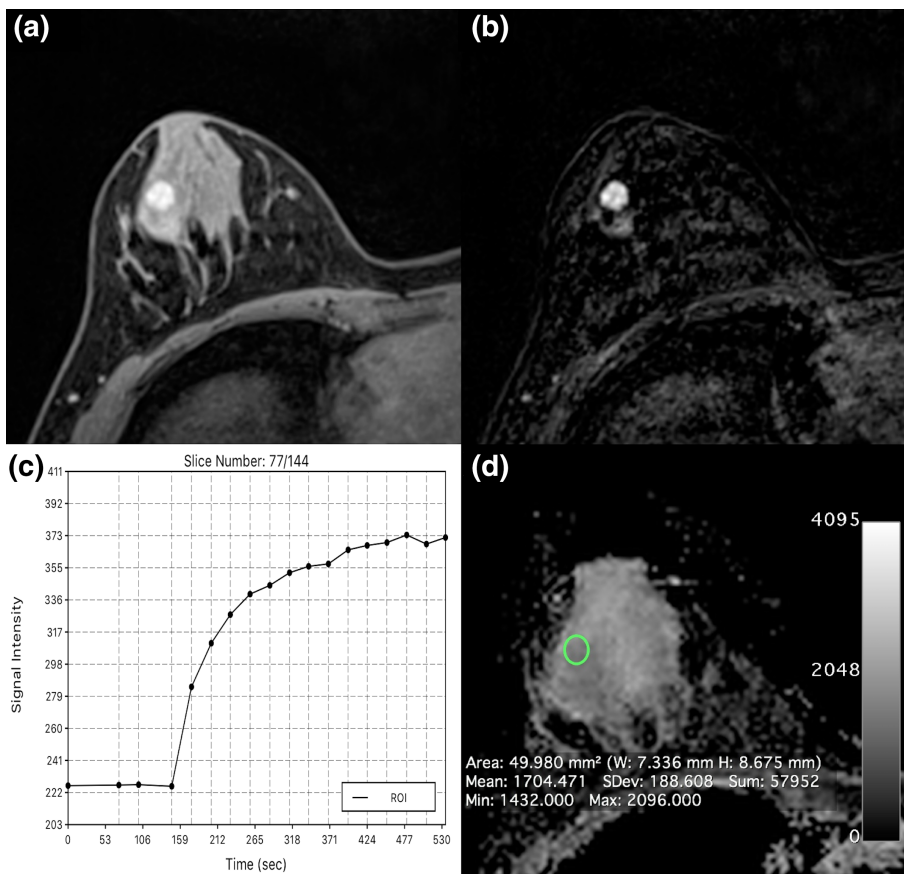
Fibroadenoma centrolateral in the left breast in a 24-year-old woman: On DCE-MRI there is a 10-mm (A) circumscribed mass with (B) an initial medium/delayed persistent homogeneous contrast enhancement with ADC values above the cutoff for malignancy ($1.704 \times 10^{-3} \text{ mm}^2/\text{s}$) evident.
